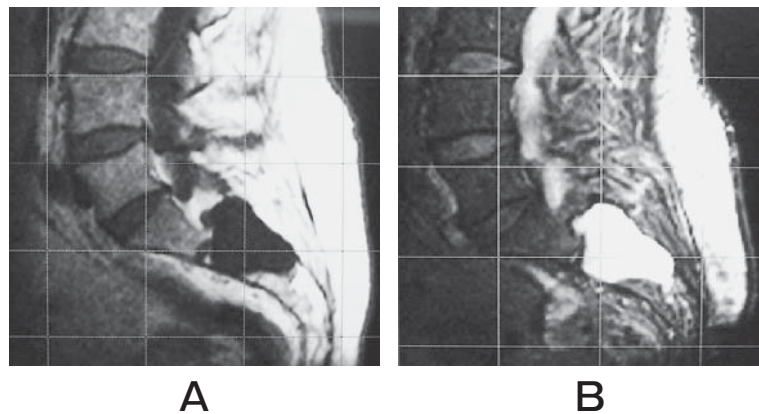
MRI of the sacral perineural cyst. A, 64-year-old female, sacral perineural cyst occurring from the S3 root. Magnetic resonance imaging demonstrated two 5 × 2-cm cystic masses occupying the sacral canal (S2), and compression of the sacral nerve roots. The figure shows a T1-weighted image; B, The figure shows a T2-weighted image.
